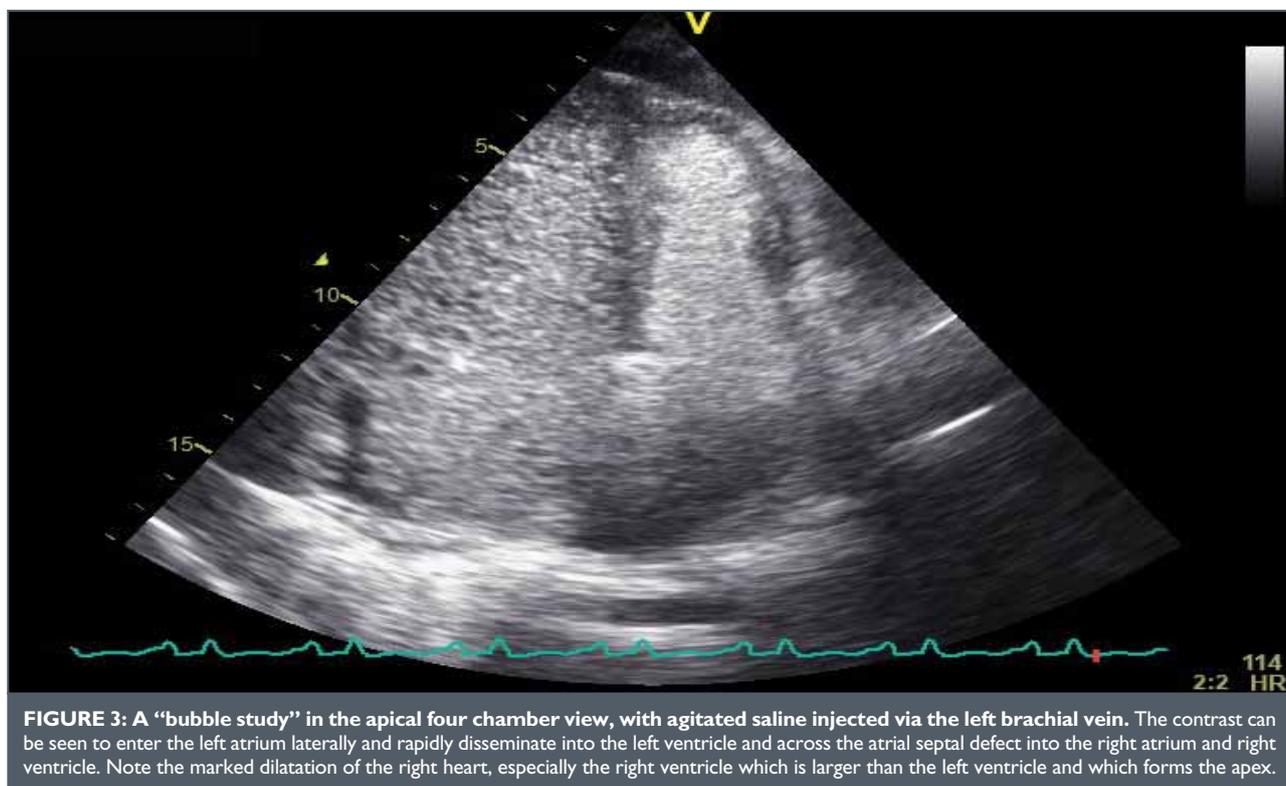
A "bubble study" in the apical four chamber view, with agitated saline injected via the left brachial vein. The contrast can be seen to enter the left atrium laterally and rapidly disseminate into the left ventricle and across the atrial septal defect into the right atrium and right ventricle. Note the marked dilatation of the right heart, especially the right ventricle which is larger than the left ventricle and which forms the apex.
